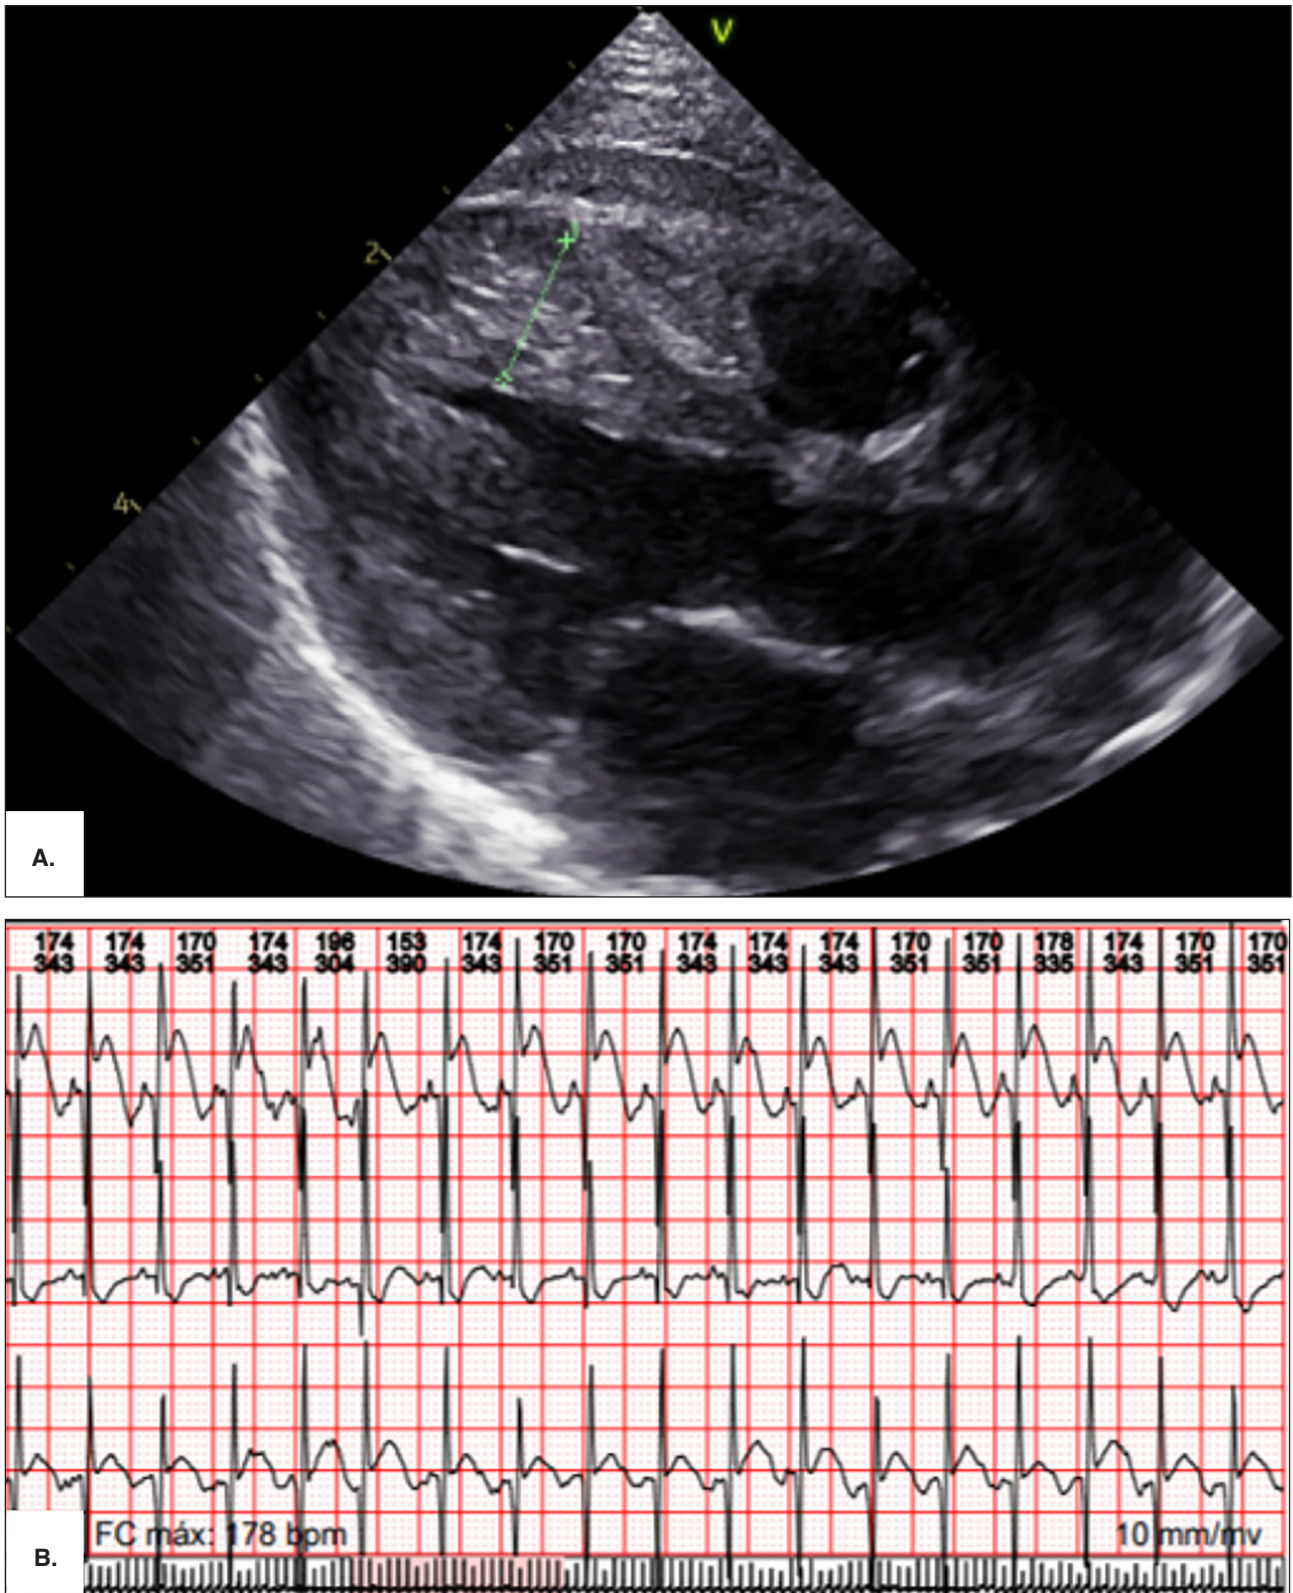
A. Echocardiogram images showing biventricular apical hypertrophic cardiomyopathy, without obstruction. B. Holter showing supraventricular tachycardia.
